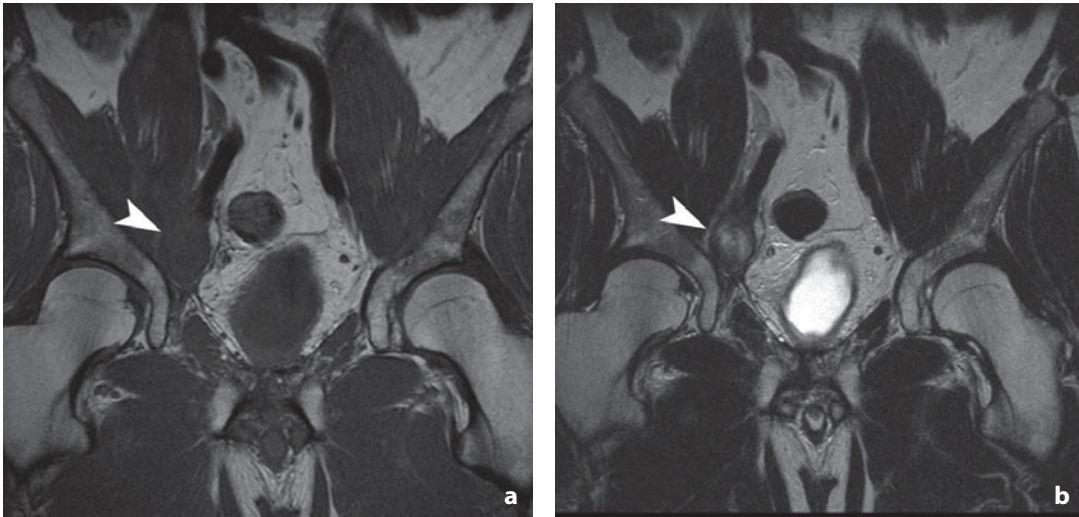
Magnetic resonance. Lymph node metastasis after radical prostatectomy. Coronal T1-weighted (a) and T2-weighted (b) images show an enlarged lymph node with heterogeneous signal intensity at the level of the right external iliac chain (arrowhead)
